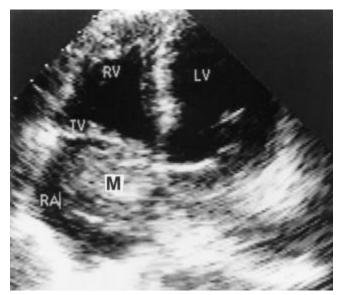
Transthoracic echocardiography (apical 4-chamber view) showing the right atrial mass attached to the interatrial septum.
